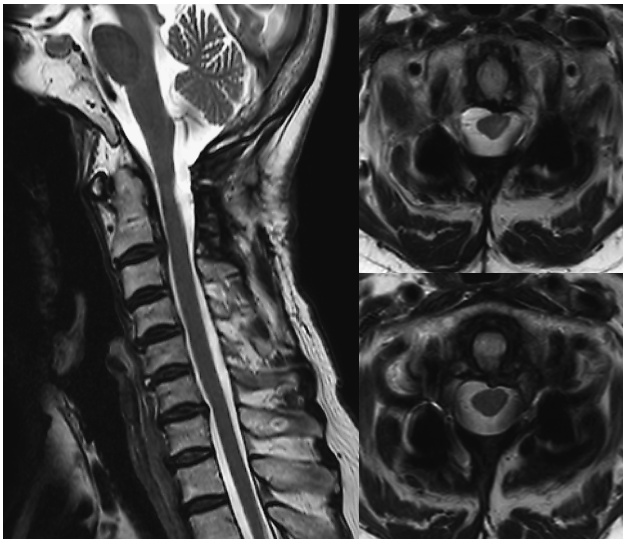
Postoperative sagittal and axial T2-weighted MRI obtained 2 years after the revision surgery (posterior resection and fusion) showing the decompressed spinal cord and no recurrence of the retro-odontoid pseudotumor lesion.
